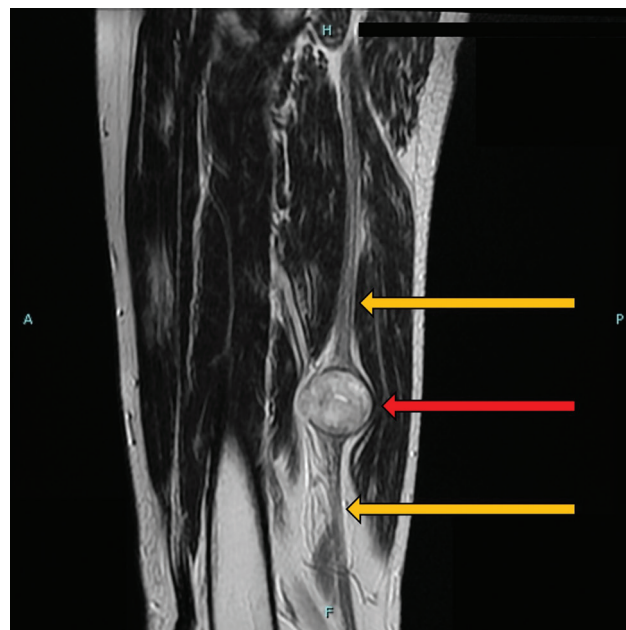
MRI T1-weighted sagittal scans that display a schwannoma (red arrow) and the sciatic nerve (yellow arrows) from which the tumor originates.
